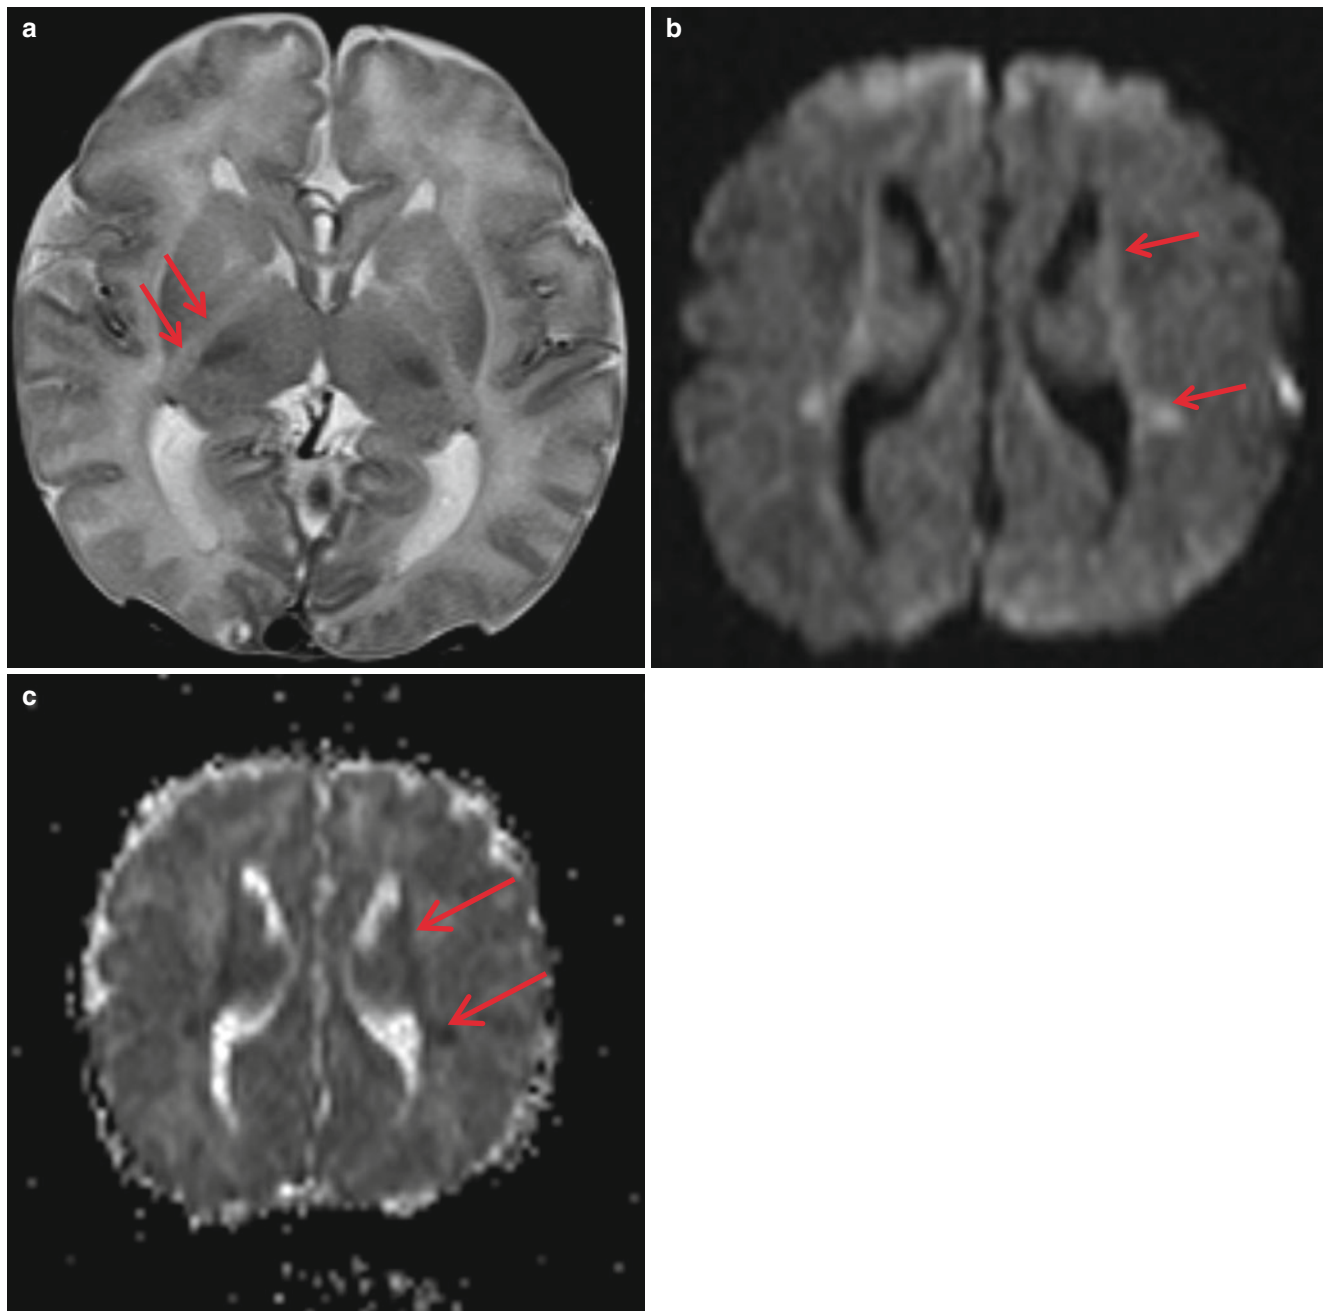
Nonketotic hyperglycinemia with seizure. (a) T2-weighted image of a 5-day-old boy showed dysplastic corpus callosum and the high-signal intensity of the posterior limb of the internal capsule
